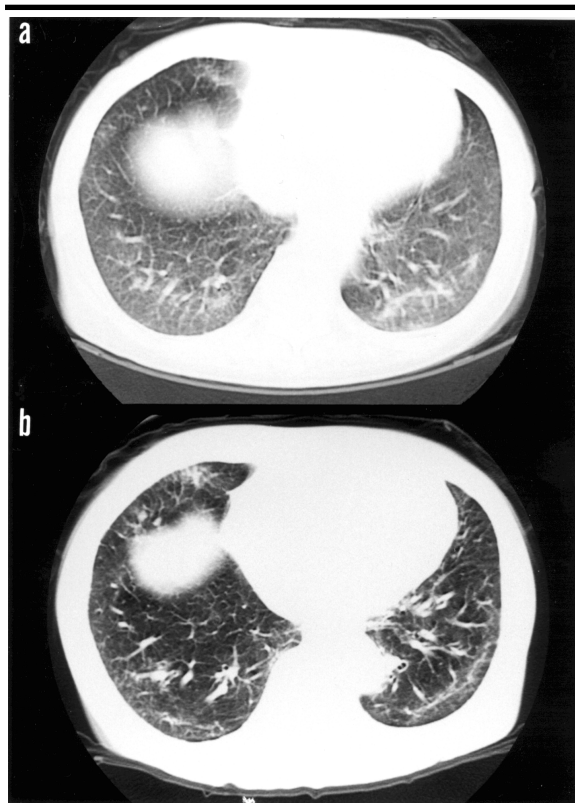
(a) Heterogeneous ground glass opacities on computed tomography of the chest upon admission; (b) resolution two months after the initiation of cyclophosphamide therapy.
